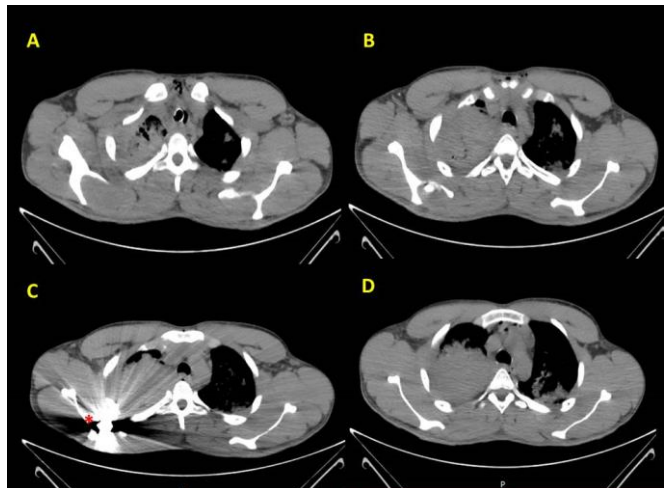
CT transverse section where hemothorax on the right and bullet lodged in scapular region (red asterisk) can be observed
